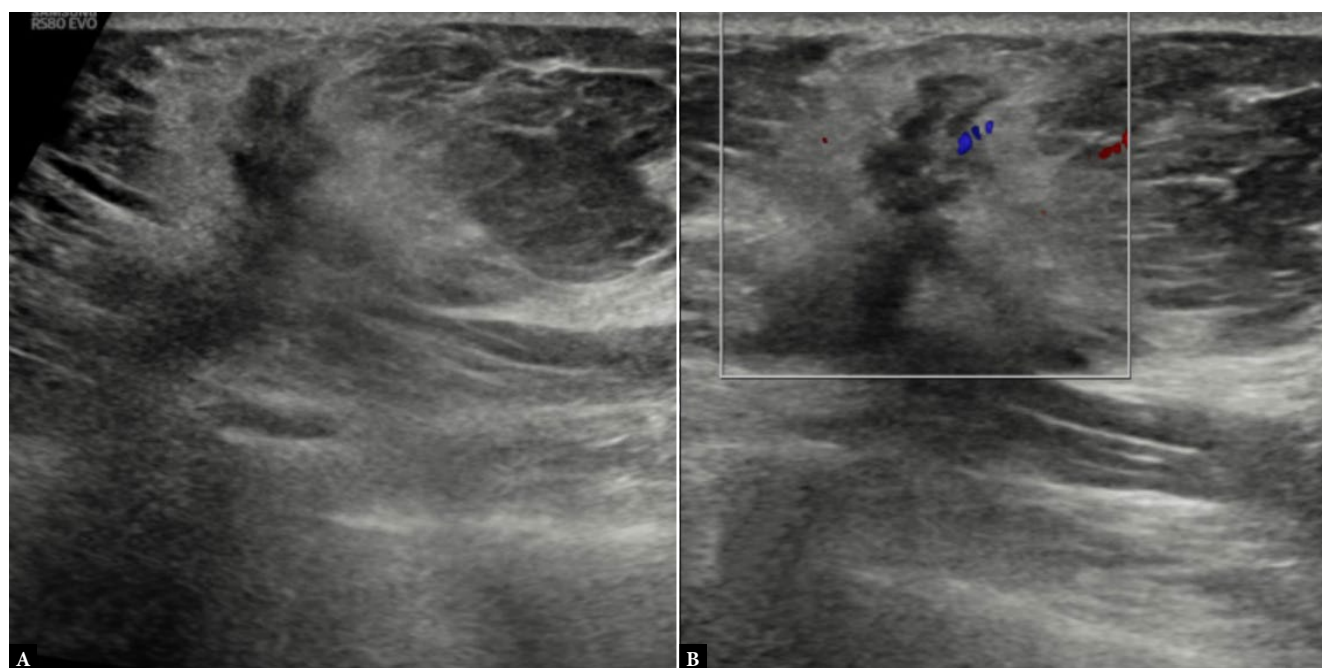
A 45-year-old female with invasive ductal carcinoma and luminal type A molecular subtype of breast cancer. Ultrasound image A. gray scale shows an irregular hypoechoic lesion, taller than wider, having spiculated margins, thick echogenic rim, and posterior acoustic shadowing, B. color Doppler shows minimal peripheral vascularity
